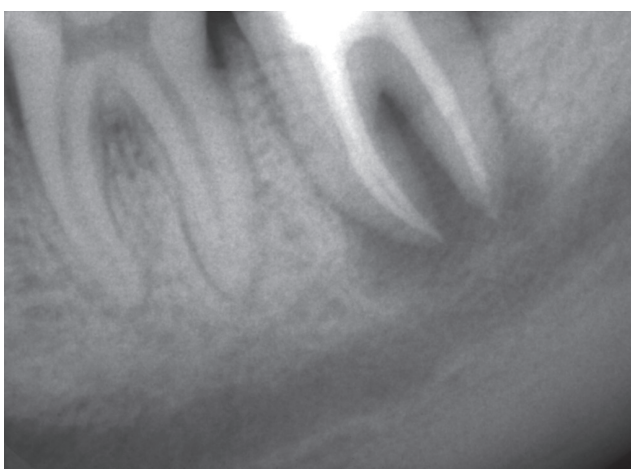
Obturation radiograph (Case 1)
